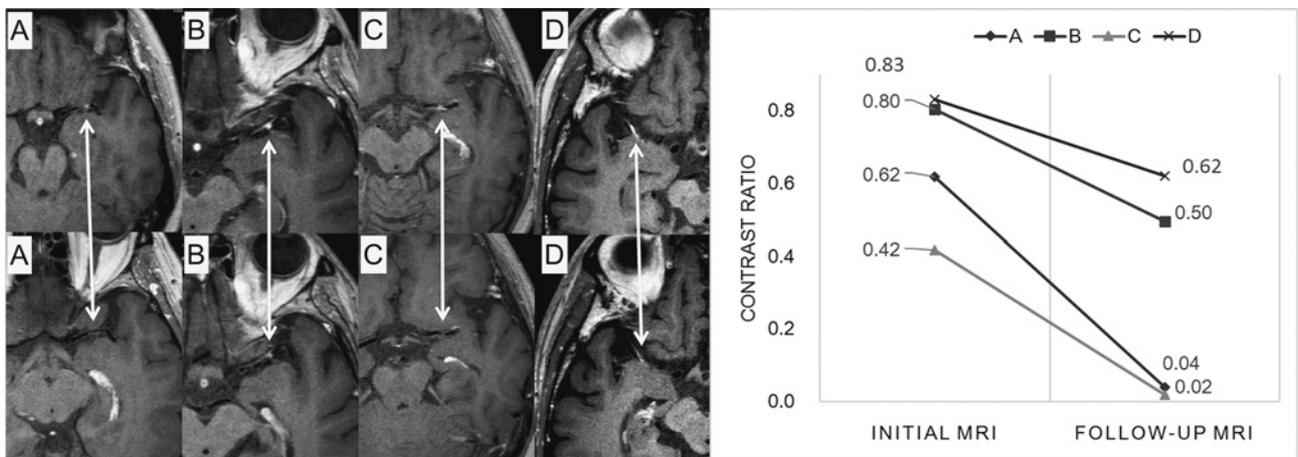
Contrast-enhanced MR images obtained soon after the onset of disease and at the follow-up stage are shown for 4 patients (A–D). Arrows indicate focal contrast enhancement at the M1 segment of the middle cerebral artery (MCA) stenotic region. The graph shows the contrast ratios of the 4 patients at the initial and follow-up stages (Fig. 3). Focal enhancements are reduced.
